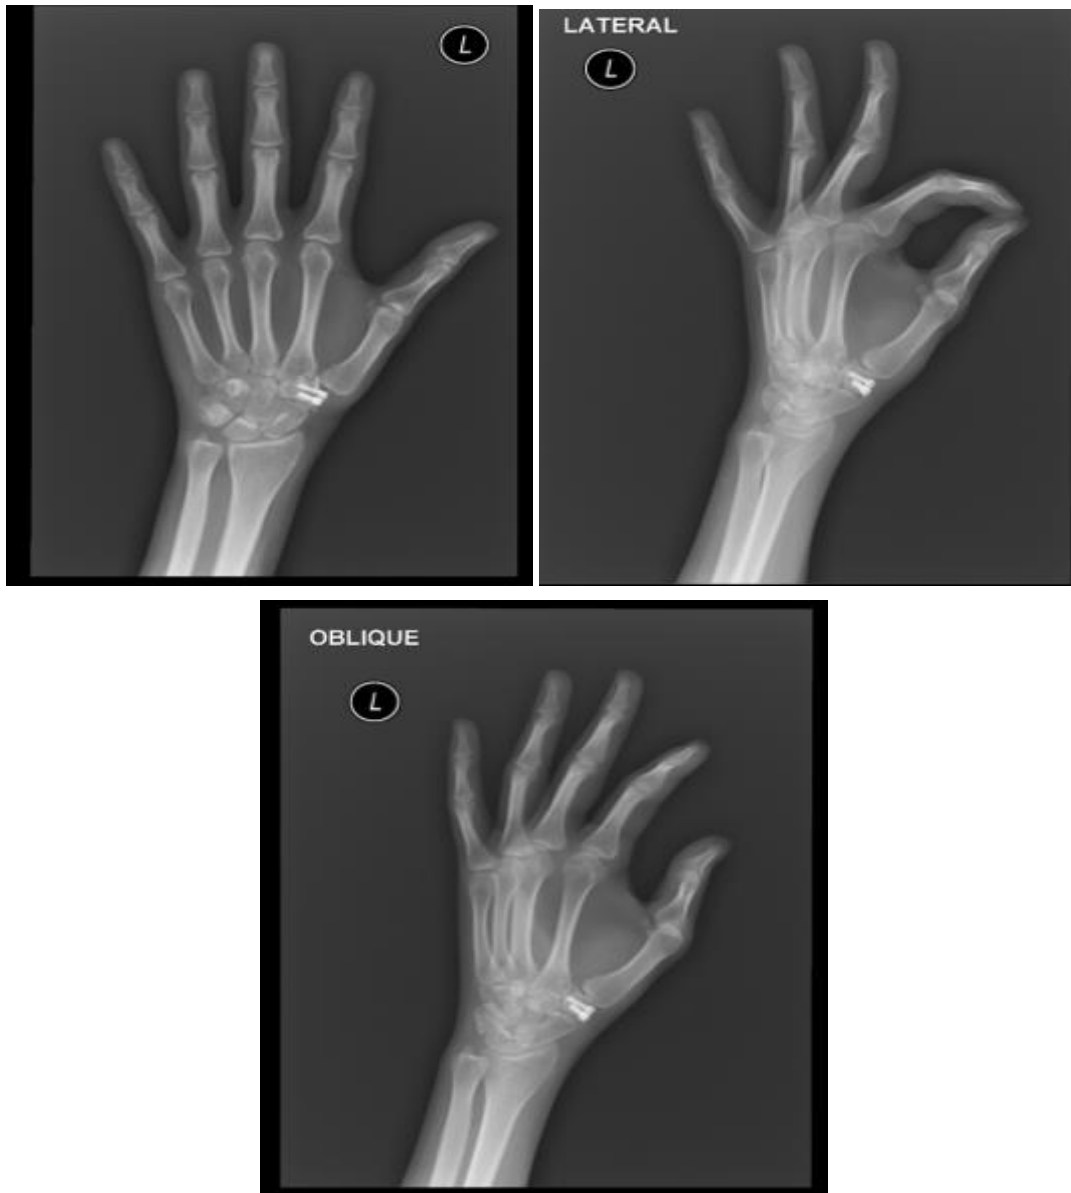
1.5 year postoperative X-ray.
